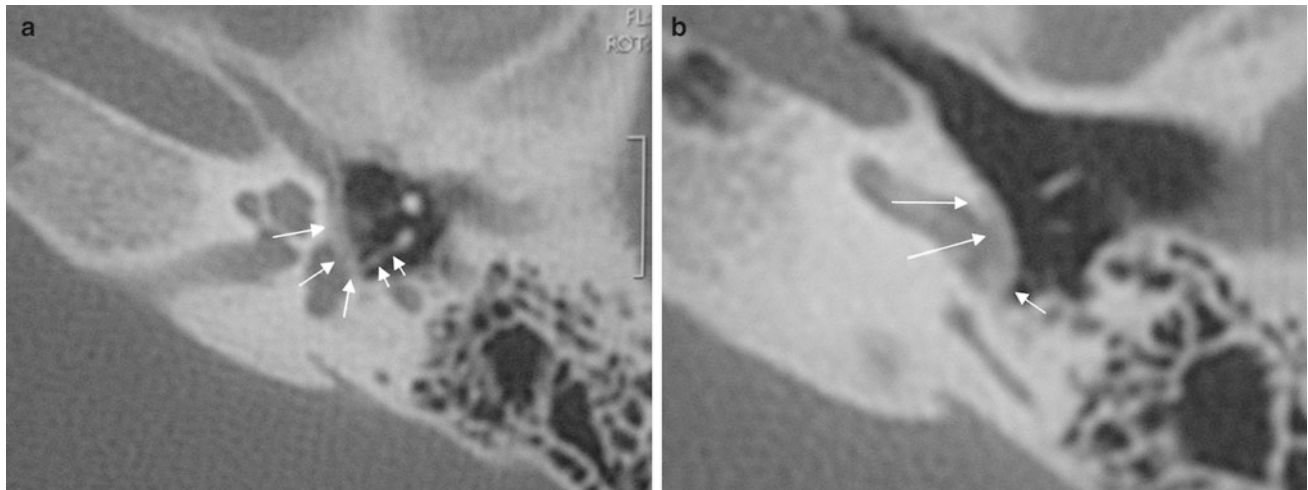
The axial CT image at the level of the oval window (a) shows an otosclerosis focus at the fissula ante fenestram extending over the oval window, and with diffuse and severe thickening of the footplate (*large arrows*). Note the postoperative status with stapedectomy and replacement by a piston, posteriorly displaced (*small arrows*). The axial CT image at the level of the basal cochlear turn and round
